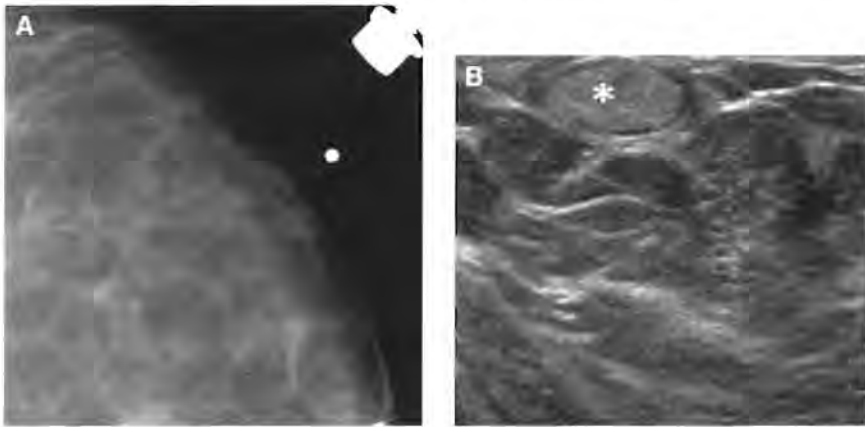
Lipoma. Mass felt on clinical and self-examination. (A) No mass is seen on a spot compression tangential mammographic view. A small metallic peller marks the site of the mass. Although no abnormality can be identified on the mammogram, the sonogram (B) shows a small lipoma (*) surrounded by fat lobules, providing a specific answer to the clinical question.
